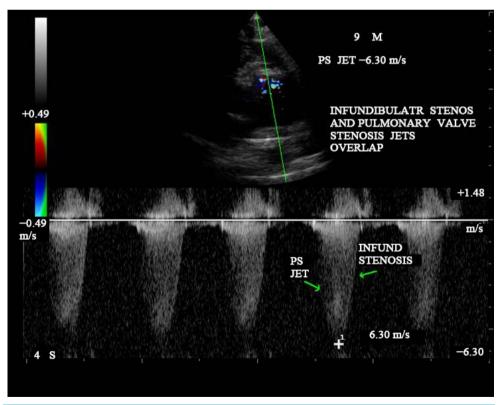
CW (continuous wave) doppler showing the infundibular stenosis jet (dagger-shaped) as an overlap with late systolic peaking in PS jet).
